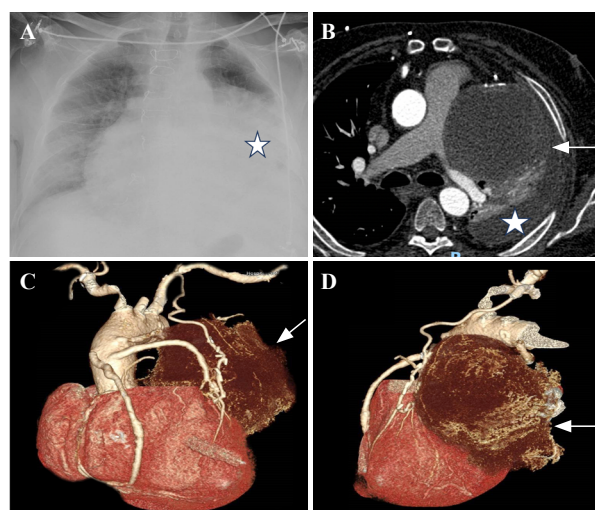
Saphenous vein graft aneurysms (SVGA) ten-year post-diagnosis imaging evaluation. A: chest X-ray 10 years after Figure 1A depicting pleural effusion in the lower two-thirds of the left hemithorax (star indicated), obscuring the mass; B: computed tomography coronary angiography (CTCA) performed 10 years after Figure 1B showing an increase in the pseudo-aneurysm size to 94 mm (arrow indicated), and suspected left hemothorax; C and D: CTCA 3D multiplanar reconstruction demonstrating a giant SVGA (arrow indicated) in close relation with lateral and posterior left ventricular walls.
